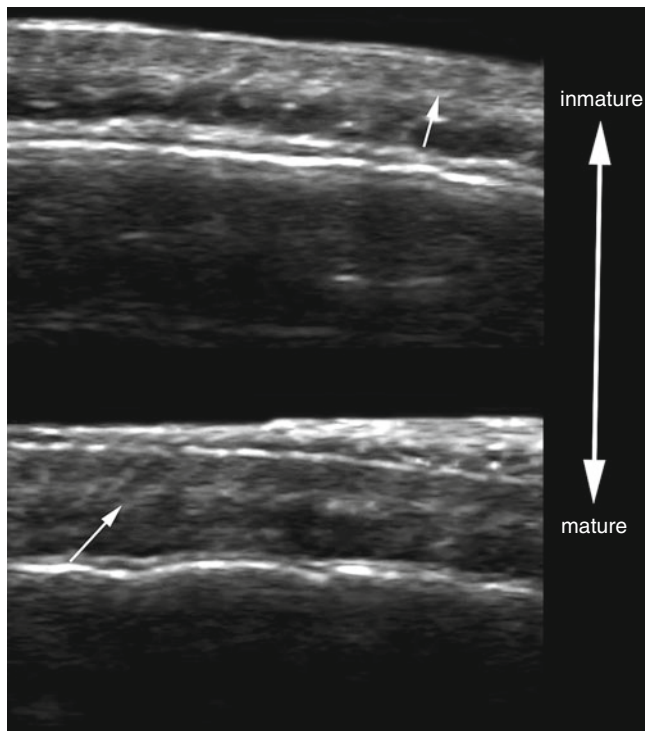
Grey scale image showing sonographic appearance of the hair follicle cycle. The arrows show the location of the hair follicles in the dermis
